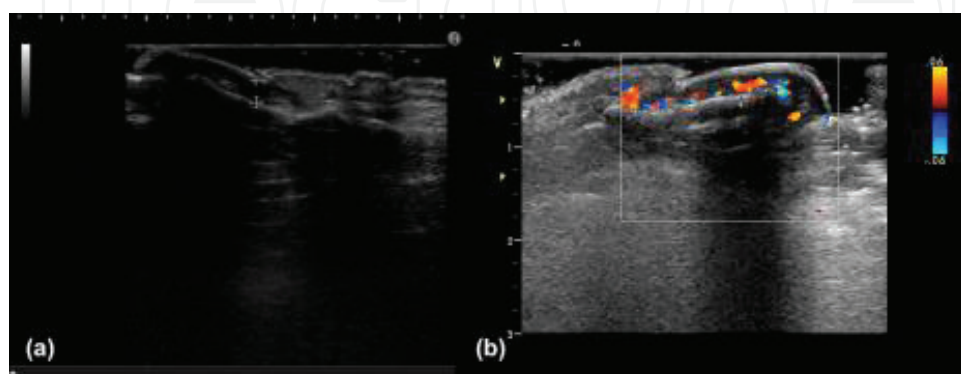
Sonography in nail psoriasis. (a) Nail psoriasis and psoriatic arthropathy with thickening of the NB, irregular wavy nail plates, hyperechoic spots in the nail plate, prominent synovium, anechoic fluid (greyscale). (b) Nail psoriasis with irregular nail plate (NP) and intense Doppler signal in the NB.
